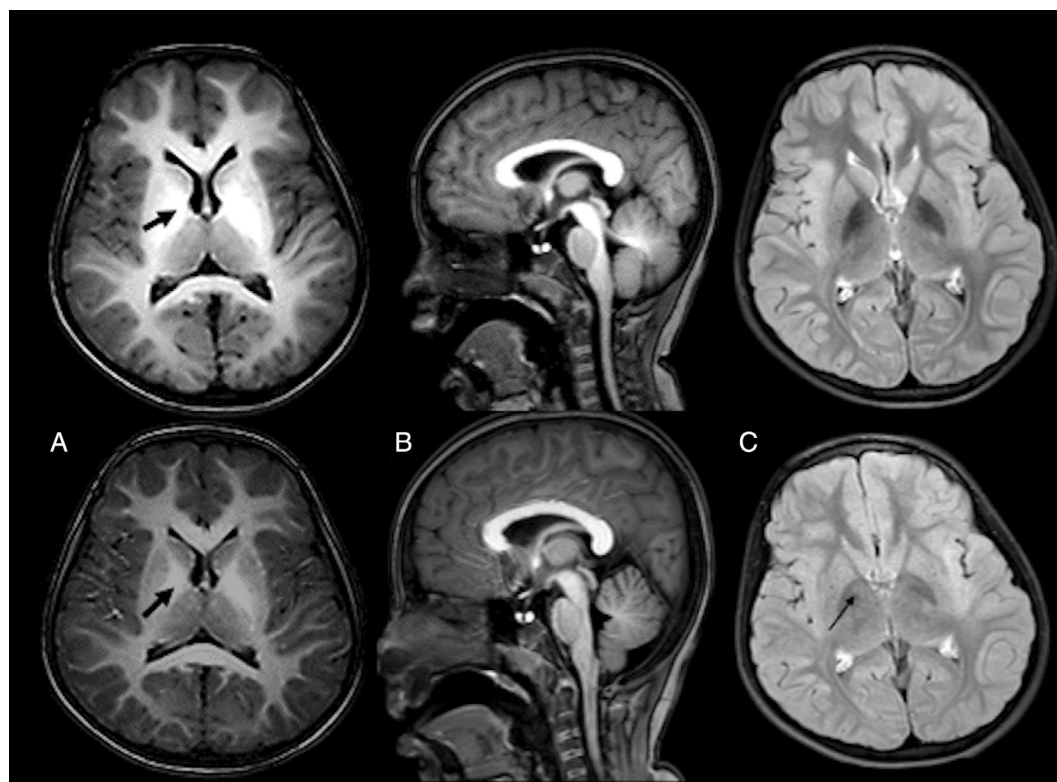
Case F20. Top panel (a = axial T1, B = sagittal T1, C = FLAIR) shows presentation scans. Bottom panel shows corresponding post treatment images. Note the reduction in swelling and T1 shortening globally within the white matter, particularly within the globus pallidi (arrows) and the tegmentum and superior cerebellar peduncles. The axial FLAIR images show concomitant reduction in the hypointensity within the globus pallidi, but with some increased central focal hyperintensity (C-arrow), which would be consistent with mild central pallidal gliosis.
